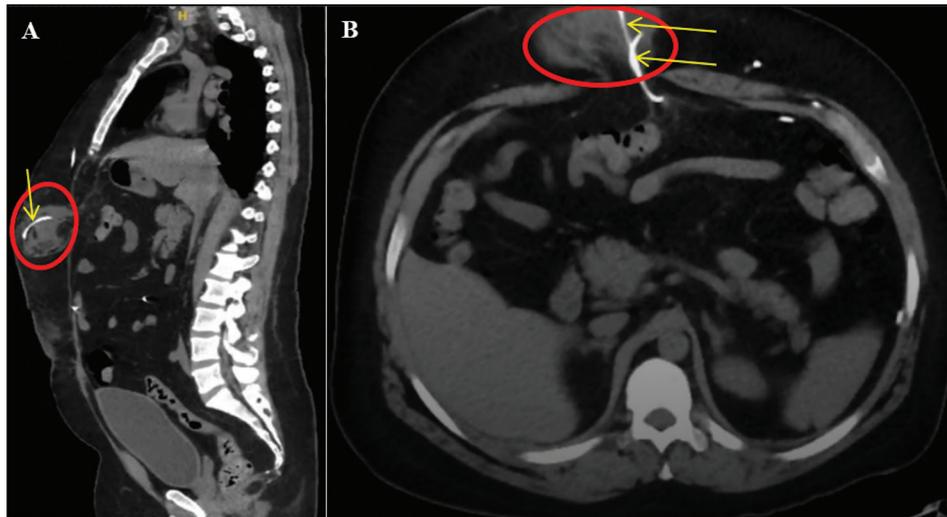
(A) Sagittal and (B) axial abdomen computed tomography images demonstrating right-sided strangulated ventral hernia (circle) containing portions of omental fat and the peritoneal catheter of patient's ventriculoperitoneal shunt (arrows)
